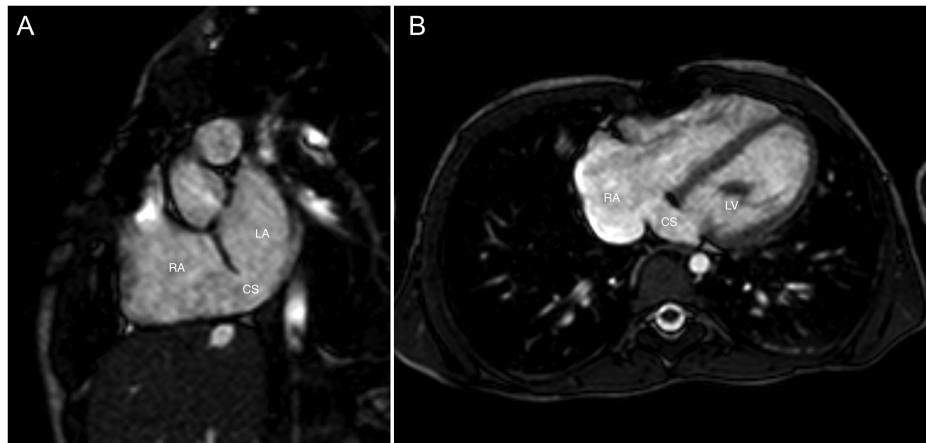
Cine balanced turbo field echo MR images in short axis view at the level of atrioventricular groove (A) and four-chamber (B) views show a dilated coronary sinus ostium with defect in the wall between the coronary sinus and left atrium. There is no PLSVC. LA, left atrium; RA, right atrium; CS, coronary sinus; PLSVC, persistent left superior vena cava.
